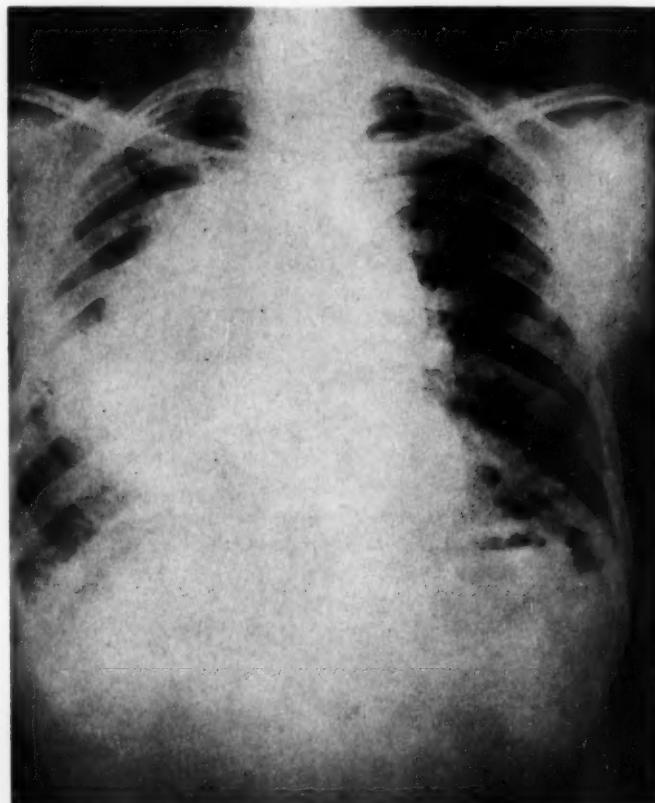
(Case 1)—Lymphosarcoma. Roentgenogram of chest showing widened superior mediastinum and large rounded shadow at right hilus, continuous with heart shadow.
